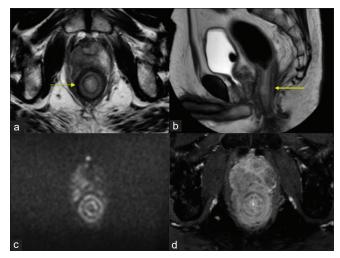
Magnetic resonance imaging pelvis (a) "target sign" appearance (arrowed) of rectal linitis plastica; (b) long anorectal thickening (arrowed) due to rectal linitis plastica causing obstruction and proximal mild rectal dilatation; (c) restricted diffusion of the mucosa and muscularis propria while no restriction on submucosa on diffusion-weighted imaging; (d) T1 axial fat suppression images of the rectum post-gadolinium
